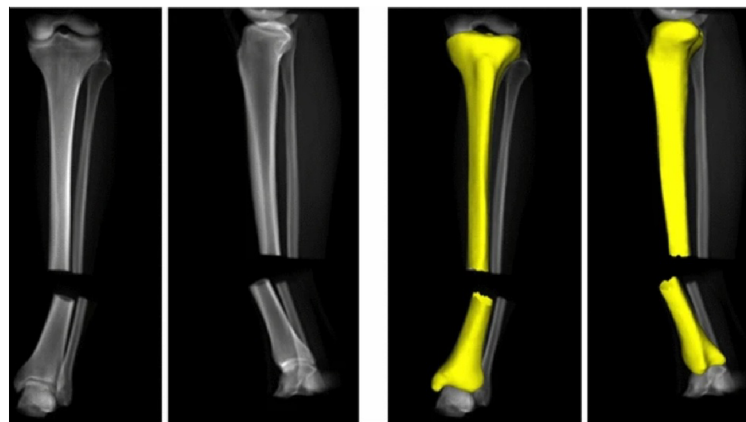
Virtual radiographs of fractured tibial bone with reconstructed models of individual fragments. Adopted from [101].
